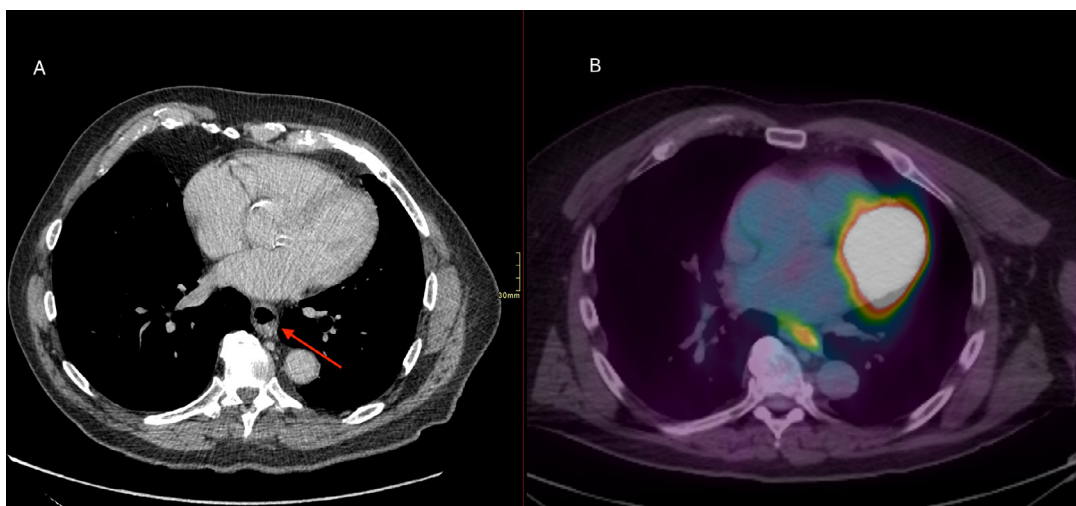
Axial contrast-enhanced CT image (A) from April 2021 demonstrated distal esophageal wall thickening (arrow). Axial positron emission tomography (PET) image (B) showed corresponding increased FDG uptake with SUV max up to 4.9.
